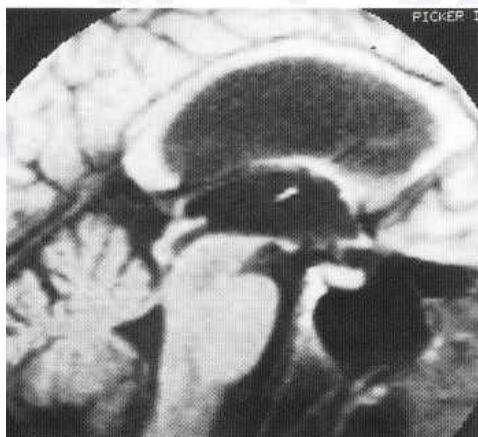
Aqueduct stenosis shown by MRI. Sagittal midline section. (Courtesy of Dr Gordon Thomson.)
